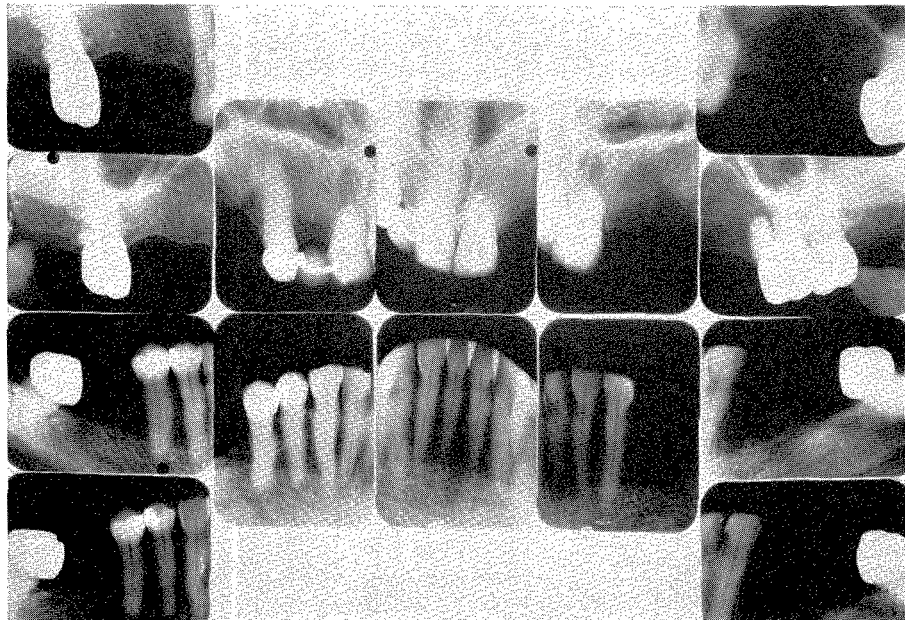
Roentgenograms of the completed work taken in November, 1937.
